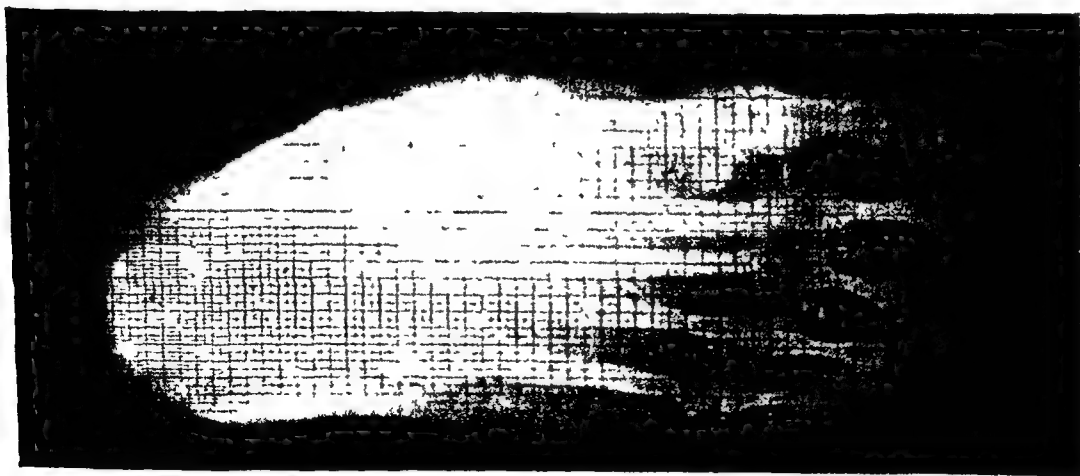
ORTHODYNAMIC WEIGHT-DISTRIBUTION FOOT-IMPRINT RADIOGRAPH Short first metatarsal foot type Excessive weight-force upon third metatarsal head, medial sesamoid bone, and great toe
